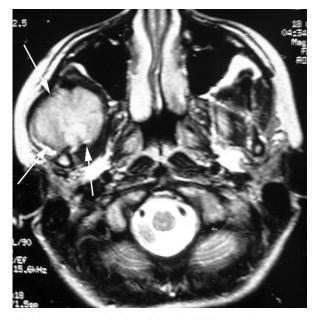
Fat-saturated T2-weighted axial images demonstrate an inhomogeneous hyperintense lesion that was located on the ramus mandible, extending through the infratemporale fossa, orbita, and soft tissue (*arrows*).
